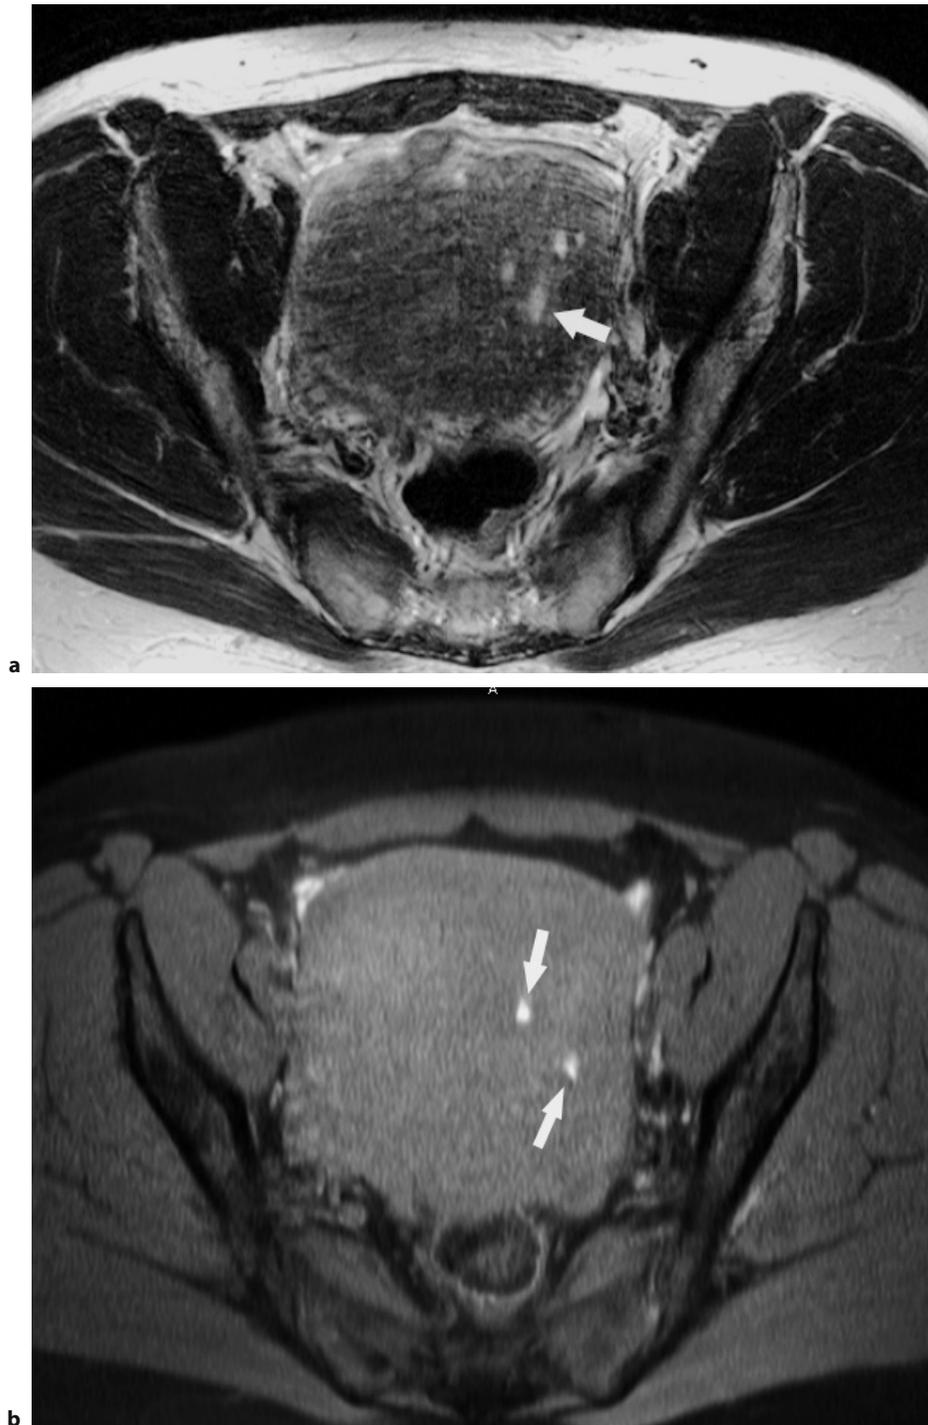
MRI of diffuse adenomyosis of the uterus. a T2-weighted transaxial image of a patient with diffuse adenomyosis of the uterus. The uterine wall is thickened, there is poor definition of the endomyometrial junction and the junctional zones blend with the myometrium. No focal mass is present. Cyst-like inclusions of hyperintense signal intensity are present (*arrow*). b Corresponding fat-suppressed T1-weighted transaxial image showing hyperintense spots within the myometrium indicating fresh blood related to the dislocated endometrial glands (*arrows*)
